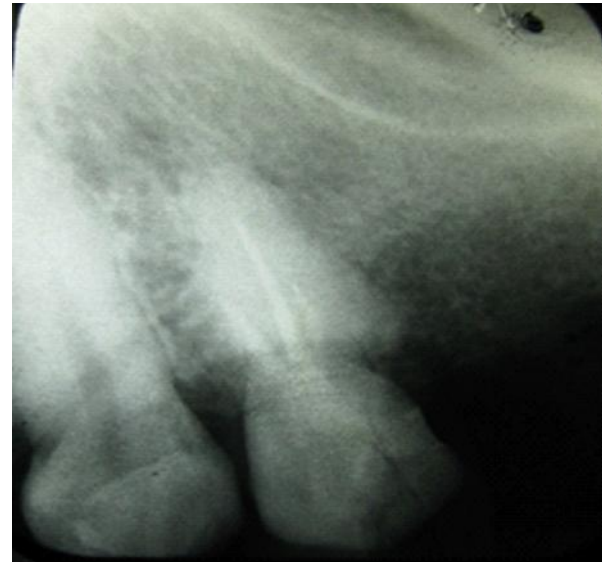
Pre-operative radiograph showing 43 with the mesiodistal width of the midportion of the root of 43 ~ the crown mesiodistal width
